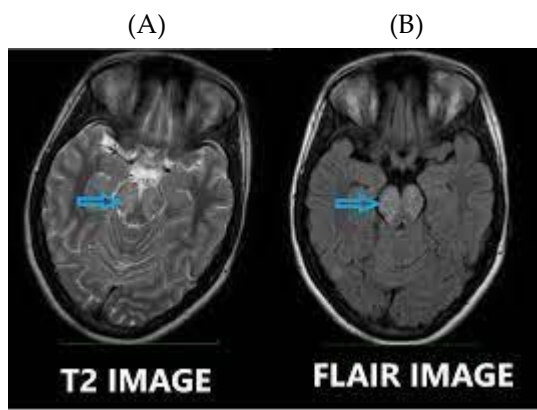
Digital T1-weighted and Axial-weighted FLAIR Magnetic Resonance Imaging, (A) A decrease in volume is observed at the mesencephalic level, with the volume of the pons preserved, and at the cortical level, there is an increase in the diameter of the sulci and fissures. (B) Mesencephalic atrophy is seen, concavity in the mesencephalic tegmentum (blue arrow)
